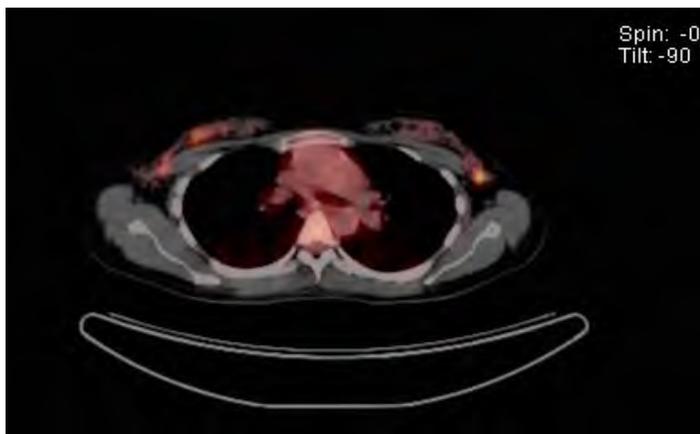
PET CT Scan of Case 1.
